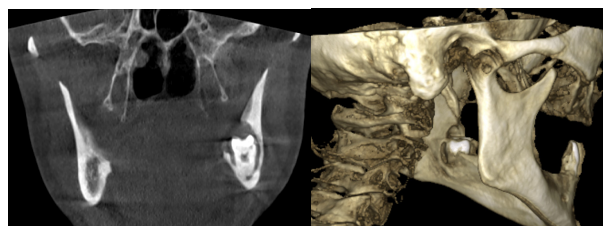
Position of the impacted left mandibular third molar on CBCT
